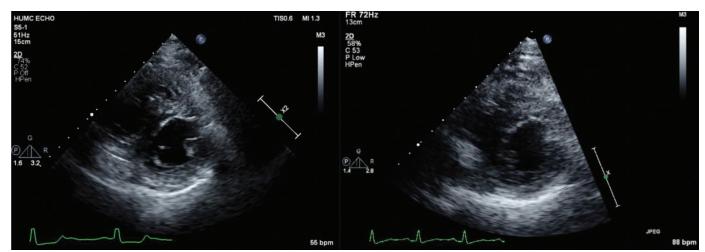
Echocardiogram 2 months prior to the transition and 4 months after intravenous treprostinil administration.
